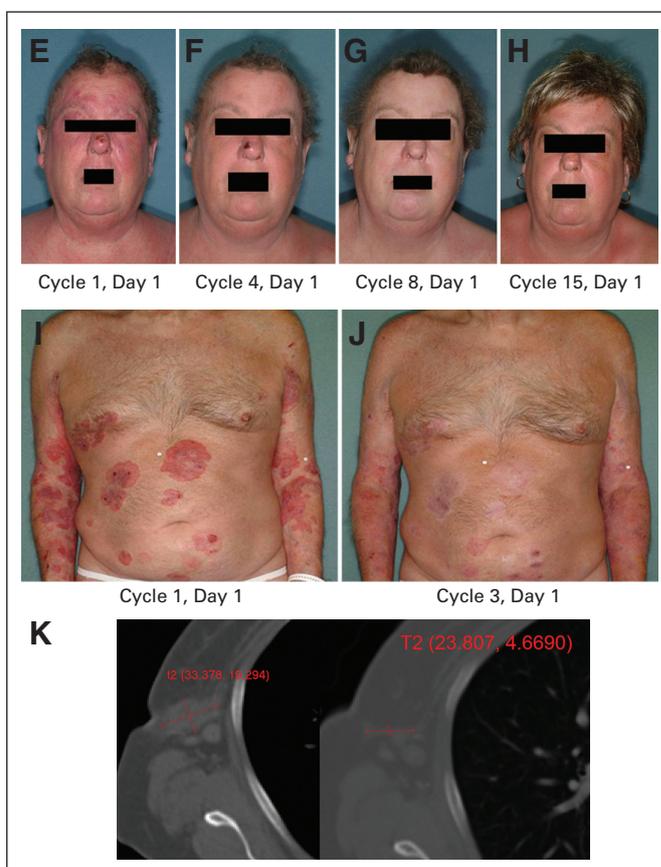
Continued. (E-H) This patient (stage IIB) experienced treatment failure of interferon, methotrexate, and deoxycoformycin; psoralens plus ultraviolet radiation (PUVA); and total skin electron beam therapies. Best response: CR; time to partial response (PR): 3 months; time to CR: 7 months; overall duration of response: 19 months. (I, J) This patient (stage IIB) experienced treatment failure of bexarotene and denileukin diftitox. Best overall response: PR; time to response: 1 month; duration of response: \geq 20 months. (K) This patient (stage IVA) had erythroderma and 34% circulating Sézary cells at baseline and had received prior PUVA, methotrexate, and bexarotene. Best overall response: PR; time to response: 1 month; duration of response: \geq 6 months. The spiral CT scan is of a lymph node; measurements of the node are as indicated.
